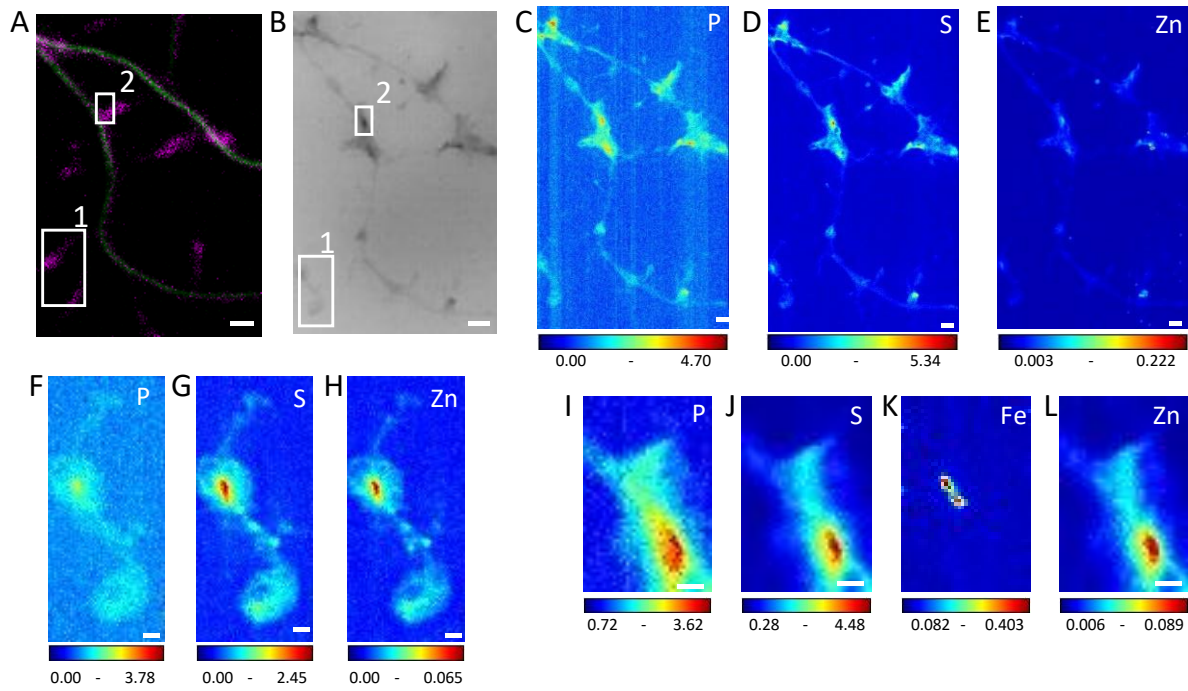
Multimodal imaging of dendrites and spines. (A) STED SiR-tubulin (green) and confocal SiR700-actin (magenta) (B) Synchrotron radiation X-ray PCI of the same area as (A). (C-E) SXRf element maps (P, S, Zn) from the same region as (A) and (B). (F-H) SXRf element maps (P, S, Zn) from the framed region 1 in (B). (I-L) SXRf element maps (P, S, Fe, Zn) from the framed region 2 in (B). Scale bars: 200 nm, except (A) and (B) 1 μm . Color scales min-max values in $\text{ng}\cdot\text{mm}^{-2}$.
